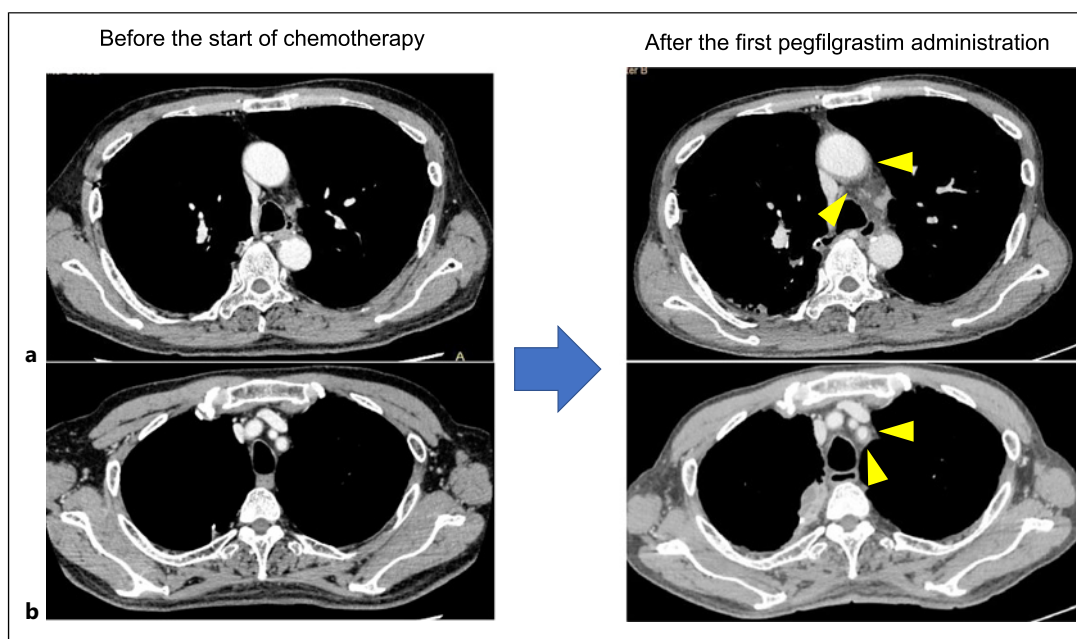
CT scan findings: The two left images were taken before the start of chemotherapy. The two in the right show wall thickening and periaortic soft tissue infiltration of the aorta (a) and left subclavian artery (b) on day 18 after the first pegfilgrastim administration.
